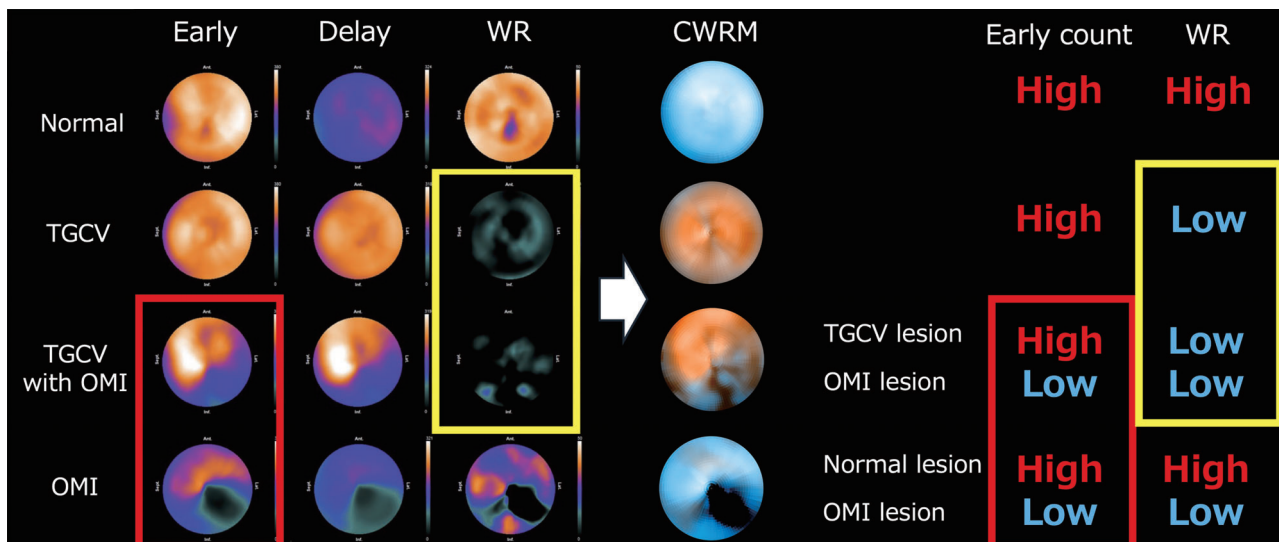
^{123}I -BMIPP SPECT polar maps of the early, time-decay-corrected delayed, and WR images and CWRM for each disease.
